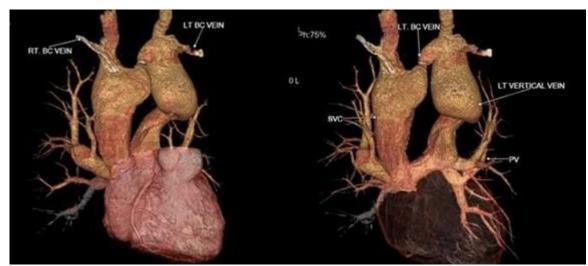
Cardiac 3D CT anterior view with all four chambers and Pulmonary veins (PV) with features as described in figure 11 (A) & (B).
